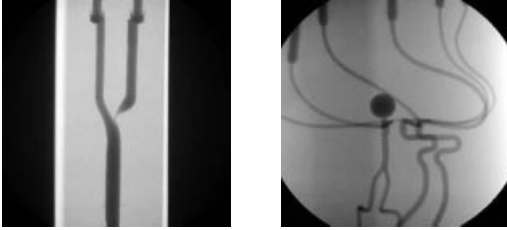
Sample X-ray projection images taken from the rotational angiography runs of the CAVP (left) and the IAVP (right). The images give an impression of the morphology and complexity of the modeled vasculature.
